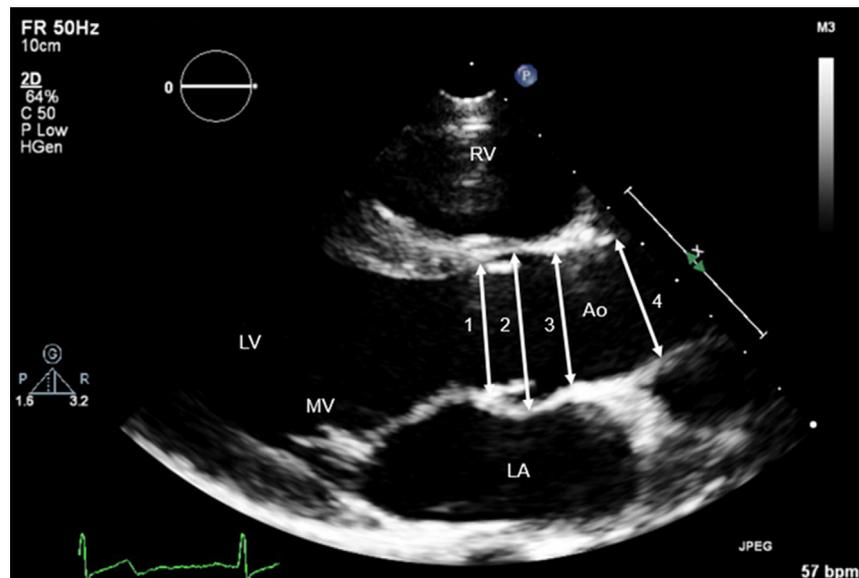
Parasternal long-axis echocardiographic image showing the aortic measurements. Ao, aorta; LA, left atrium; LV, left ventricle; MV, mitral valve; RV, right ventricle; SoV, sinuses of Valsalva; STJ, sinotubular junction. The aortic root and ascending is measured at 4 standardized places, inner-edge to inner-edge technique in end-systole as indicated by the arrows: the aortic valve annulus (1); SoV (2), STJ (3) and the ascending aorta at its widest diameter, at least 2cm above the STJ (4).
